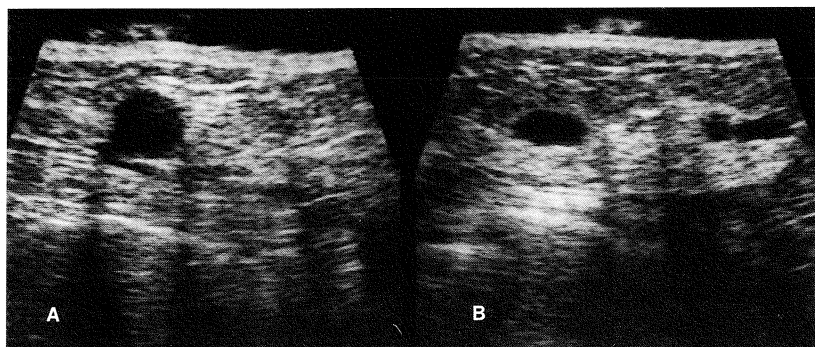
Ultrasound scans of the (A) right and (B) left breast of a woman with multiple cysts show multiple well-defined anechoic masses.
